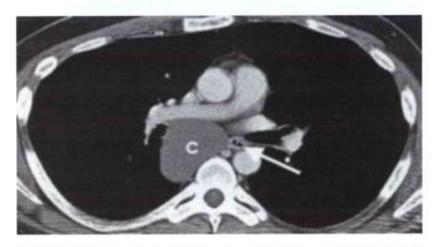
Esophageal duplication cyst. CT scan of a 45-year-old woman shows a subcarinal cystic structure (*C*) of homogeneous fluid attenuation in contact with the esophagus (*arrow*). The appearance is indistinguishable from that of a bronchogenic cyst.
